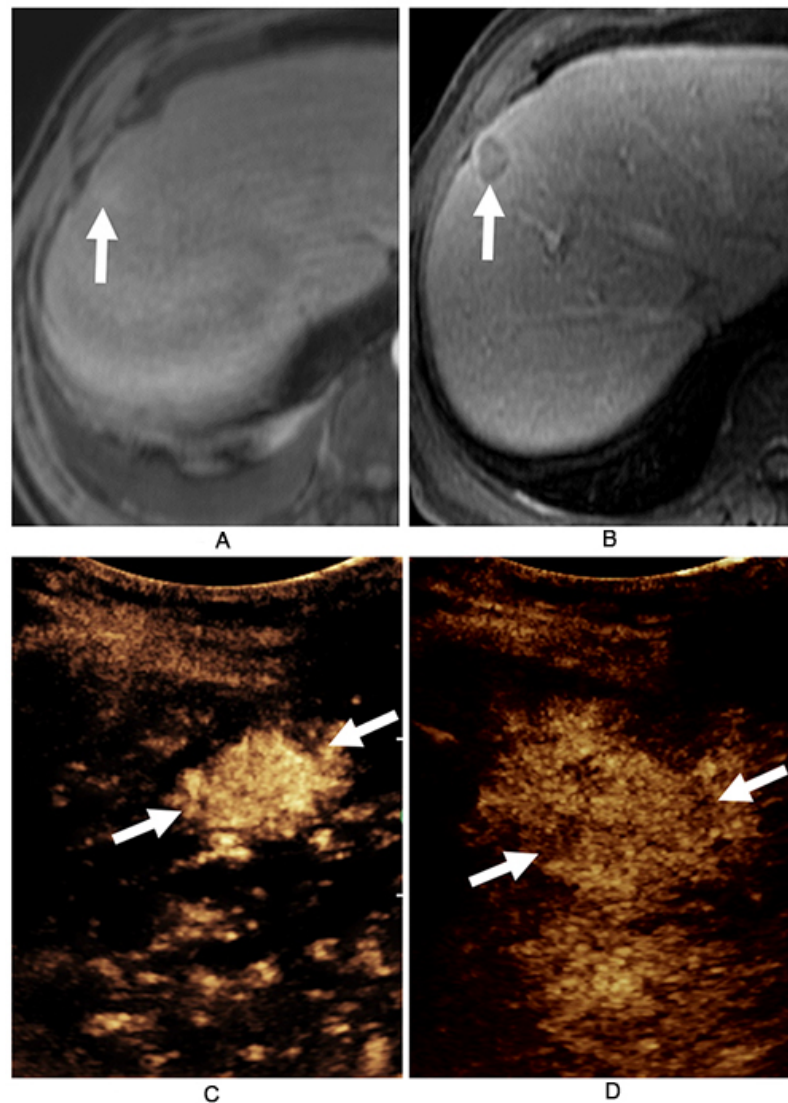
Superior demonstration of APHE with CEUS. MRI of a 2.3-cm liver lesion in a 71-year-old man with NASH cirrhosis shows minimal to absent APHE (arrow in A) but with clear washout and enhancing capsule at portal venous phase (arrow in B), meeting criteria for LR-4 with CT/MRI LI-RADS. At CEUS, the lesion shows clear APHE (arrows in C) and washout that is mild and late (arrows in D), meeting criteria for LR-5 with CEUS LI-RADS, diagnostic of HCC. The lack of clear APHE on the MRI was probably due to slightly early acquisition; the dynamic continuous acquisition of CEUS is not susceptible to this shortcoming.
